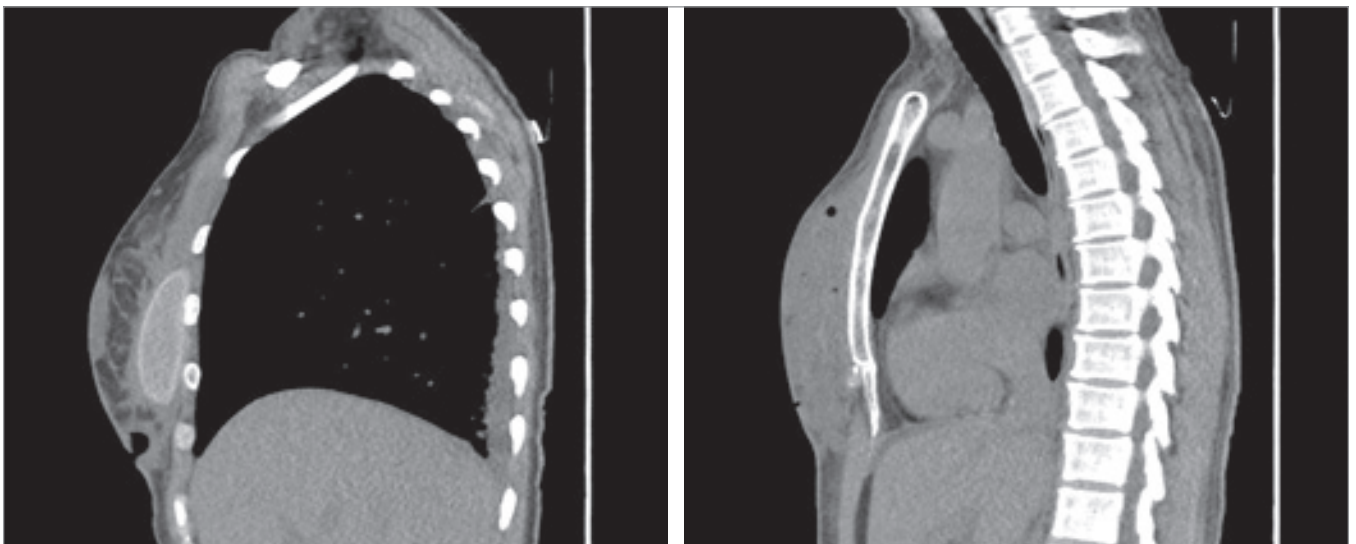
Initial CT scan – implants, pre-implants collection, gas bubbles and reactive pleural effusion.
